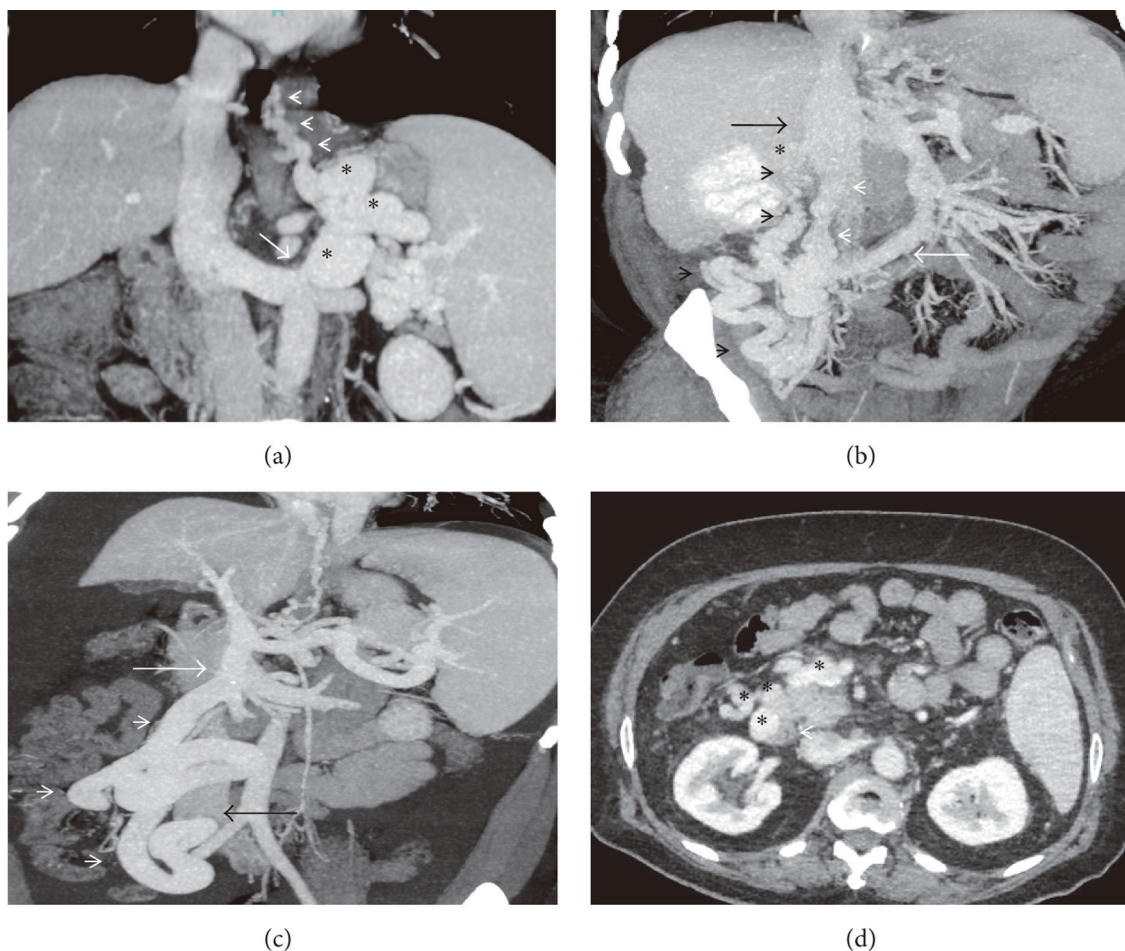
Maximum-intensity-projection, contrast-enhanced CT imaging of various NVEPS. (a) Coronal-oblique image showing a tortuous gastro-lieno-renal shunt (asterisks) draining multiple gastroesophageal collaterals (arrowheads) into the superior aspect of the left renal vein (arrow); (b) Coronal image demonstrating a mesorenal and a mesocaval shunt in the same patient (black and white arrowheads, respectively). Asterisk: right renal vein; black arrow: IVC; white arrow: superior mesenteric vein (double portosystemic shunts); (c) Coronal-oblique image demonstrating a dilated and tortuous mesocaval shunt (arrowheads) communicating between the superior mesenteric vein (white arrow) and the inferior vena cava (black arrow); (d) Axial image showing multiple duodenal and paraduodenal collaterals (asterisks). Arrowhead denotes the duodenum. [Philips CA, et al. A Comprehensive Review of Portosystemic Collaterals in Cirrhosis: Historical Aspects, Anatomy, and Classifications. *Int J Hepatol.* 2016;2016:6170243. doi: 10.1155/2016/6170243. Creative Commons license to copy. No alterations were made to original photos]. CT, computed tomography; NVEPS, non-variceal extrahepatic portosystemic shunts.
